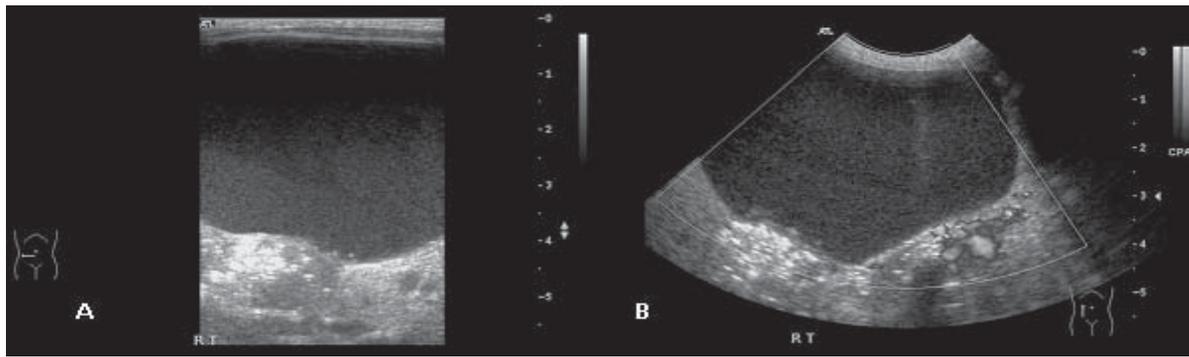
Patient 2: Cystic mass with internal echoes and an echogenic nodule with calcification. No internal vascularity on colour Doppler sonography.
